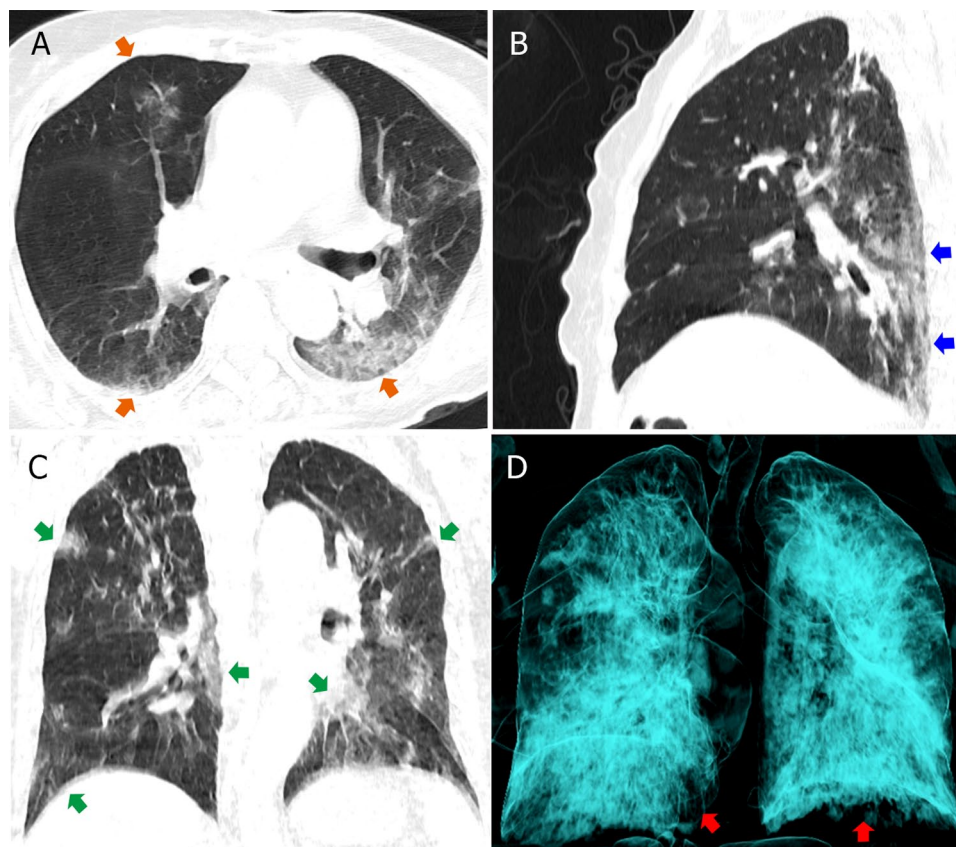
Chest CT of a PD patient with COVID-19. (A) axis scan; (B) sagittal scan; (C) coronal scan; (D) three-dimensional reconstruction.
